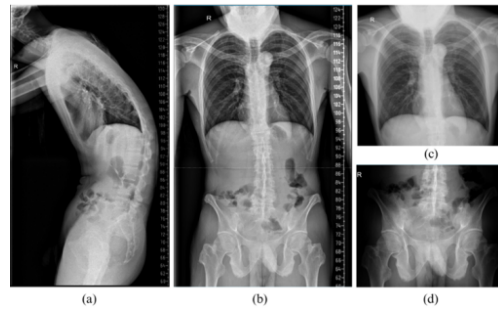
X-ray photo of the patient (a)(b) *stretching spine AP/Lateral* (c) thorax AP (d) pelvis AP.
